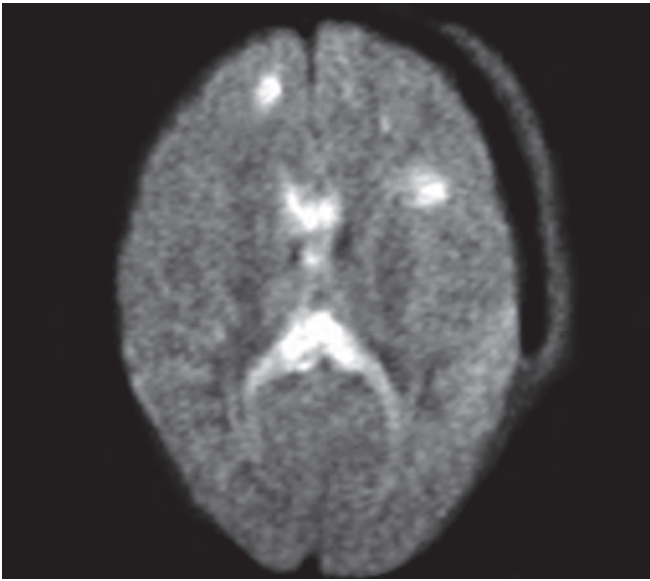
MRI diffusion sequence demonstrating multiple foci of abnormal increased signal at the grey-white matter junction and within the corpus callosum in a patient with DAI
